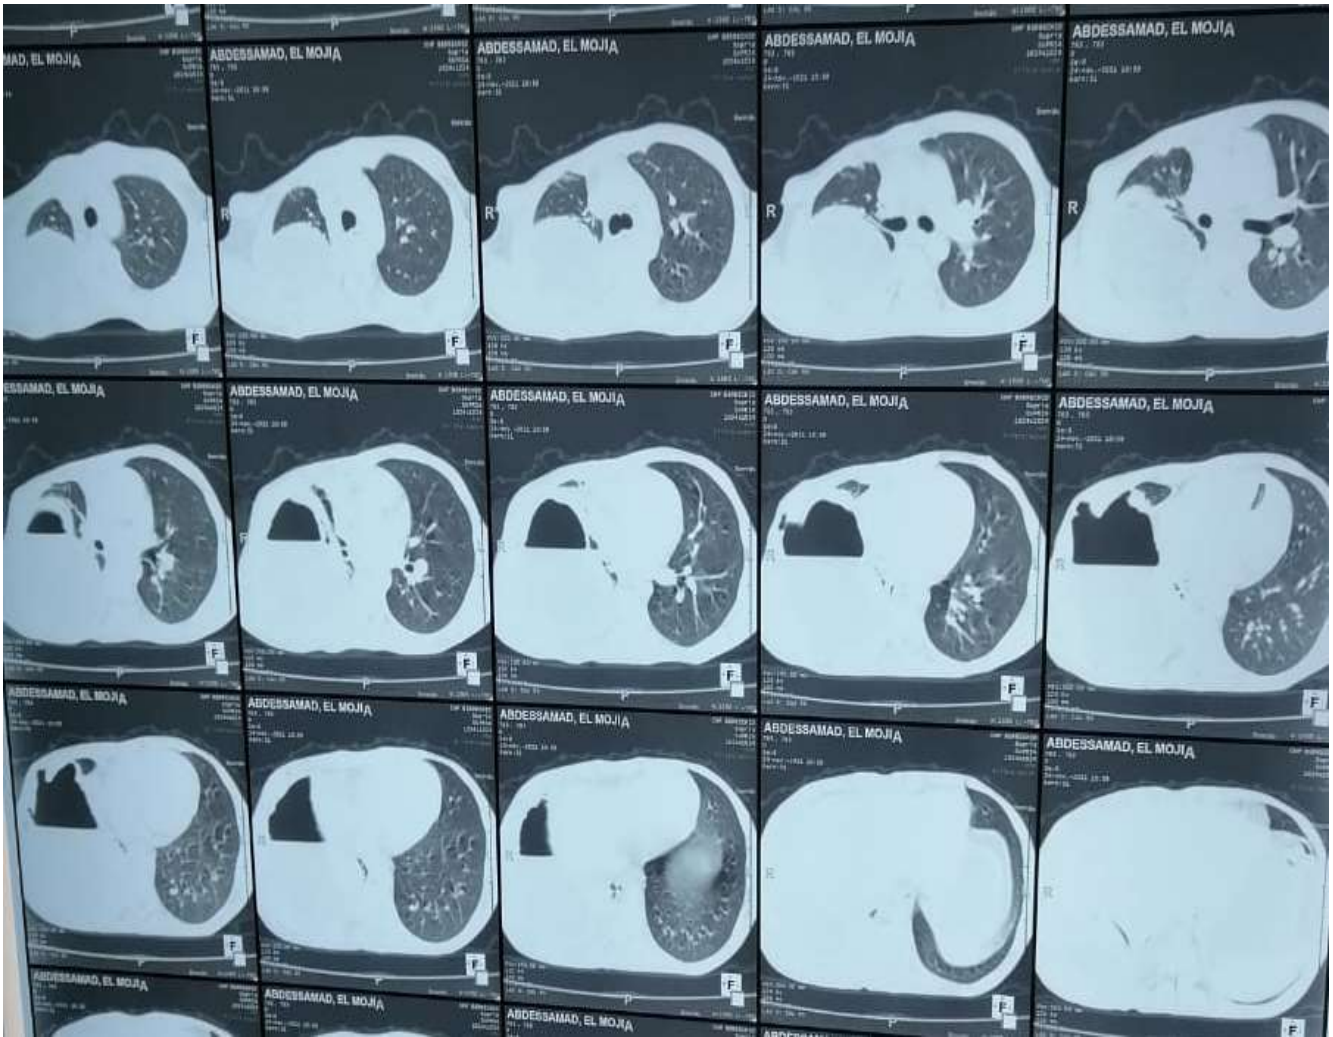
CT-Scann in the right showing a right hydropneumothorax
